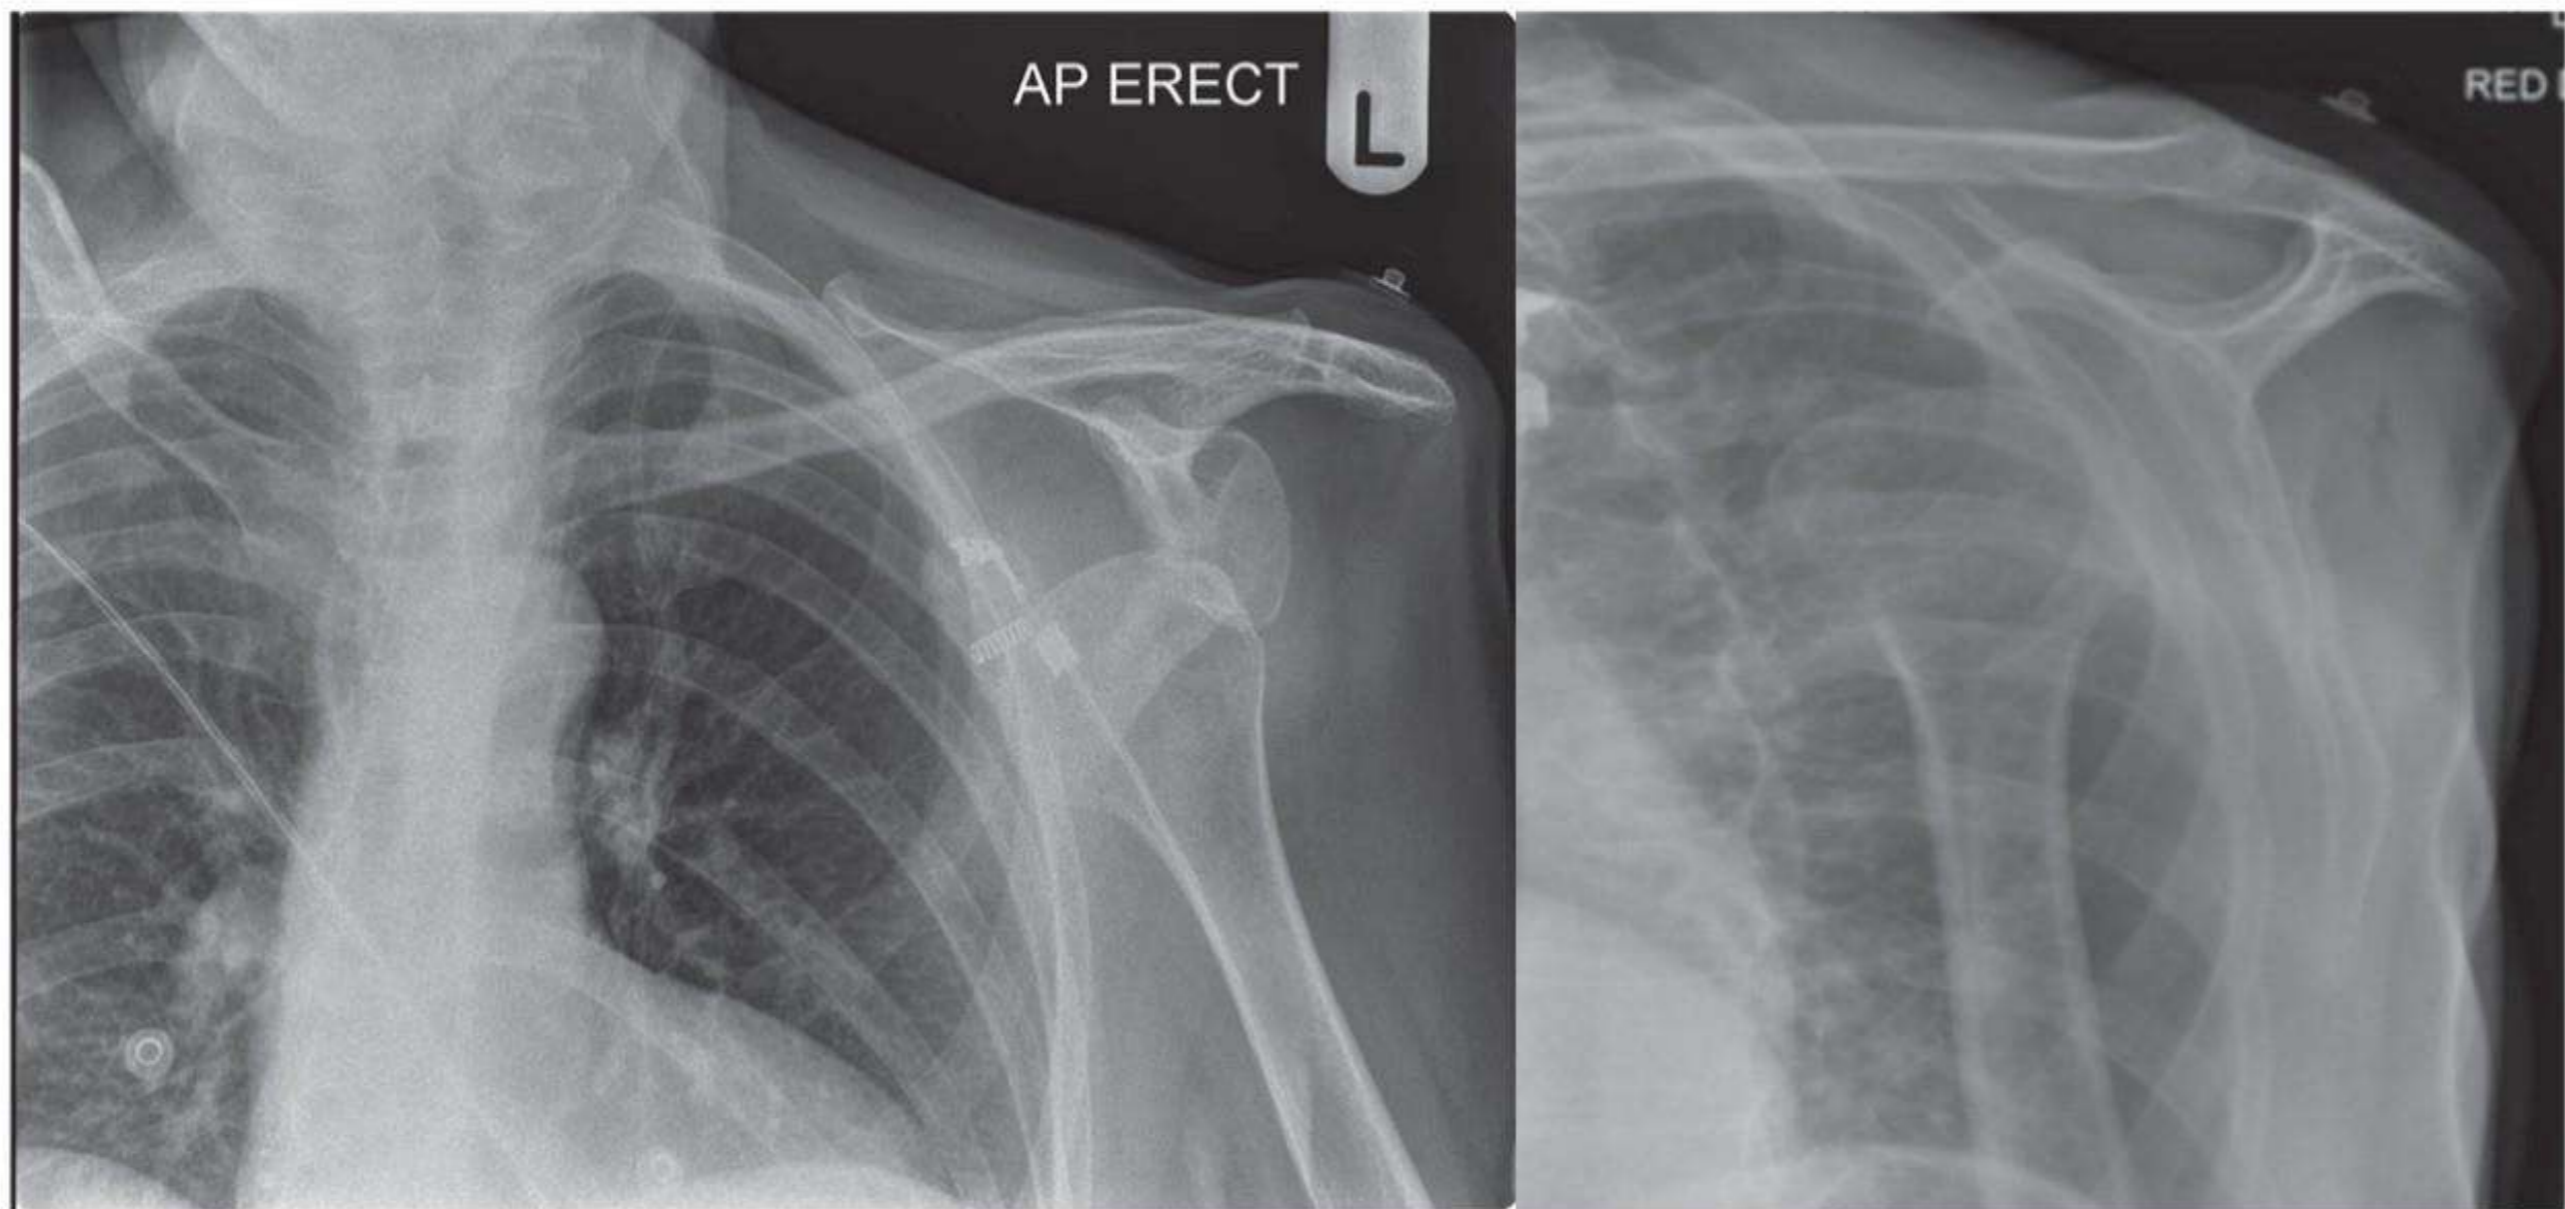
Left shoulder radiographs
